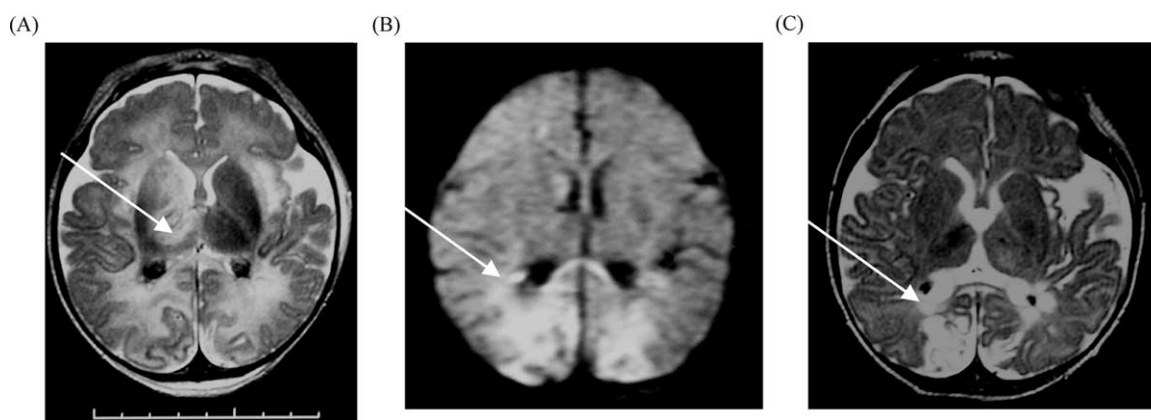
Axial T2-weighted magnetic resonance scan (A) of the infant on the fifth day after collapse shows bilateral intraventricular haemorrhage, with multiple signal abnormalities in the right caudate, putamen and thalamus (arrow); less severe changes are apparent in the left deep nuclear structures; bilateral signal abnormalities are apparent in the parieto-occipital cortex and subcortical white matter. Diffusion weighted imaging (B) at the same time as in 'A' shows regions of marked restriction in diffusion in the posterior cerebrum (arrow). Later axial T2-weighted imaging (C) at 2 months of age shows cystic necrosis and atrophy in the occipital regions (arrow), signal abnormality in the basal ganglia (right greater than left), and resolving intraventricular hemorrhages.
